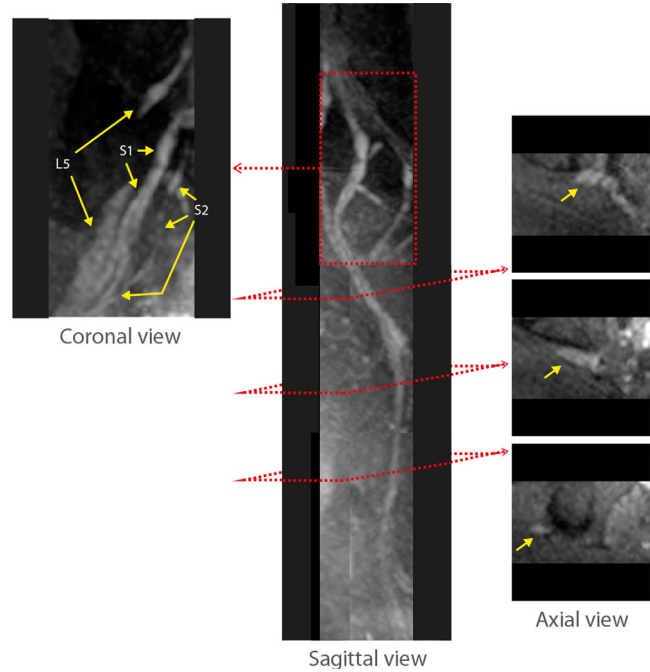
Isotropic resolution multiview DWI of lumbosacral and sciatic nerves with phase-corrected DP 3D TSE. Coronal, sagittal, and axial views of the iso-DWI acquired with isotropic resolution phase-corrected DP 3D TSE show L5, S1, and S2 nerve roots and branches as well as the postjunction sciatic nerve running down in the pelvic region.
